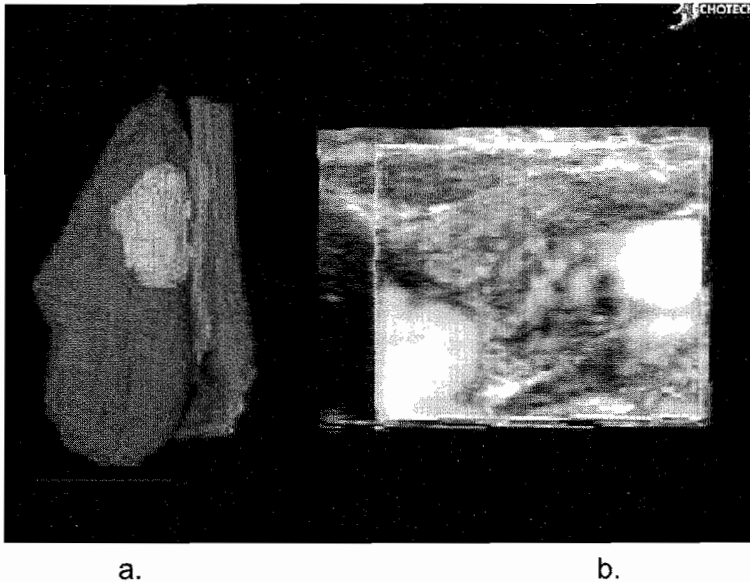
3-D reconstruction and Power Doppler images of thyroid carcinoma.
